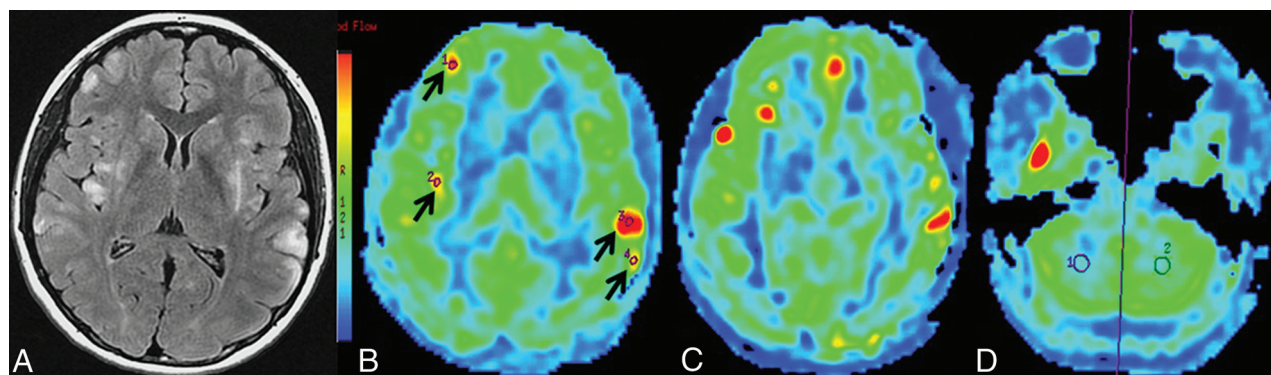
Case 11, a 20-year-old female patient at the acute stage (5 days after the onset of symptoms). A, Axial T2 FLAIR shows multiple lesions located in right frontal and bilateral insular lobes, as well as the bilateral temporal lobes. B, 3D-pCASL demonstrates increased CBF, consistent with involved regions on axial T2 FLAIR (black arrows). C, Other lesions also show hyperperfusion in different affected areas. D, ROI site selection for bilateral cerebellum CBF on the pCASL CBF color map.
